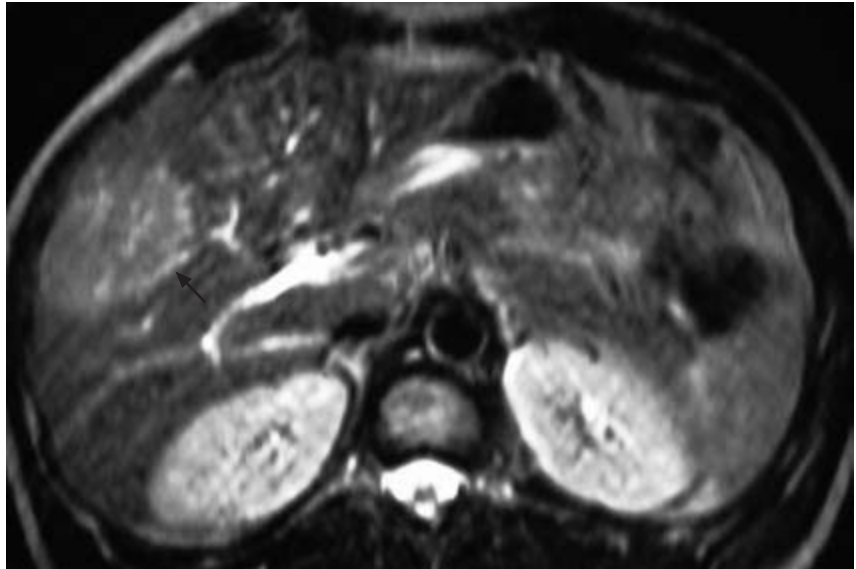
Focal nodular hyperplasia. MRI shows a liver mass in the right lobe (arrow), homogeneously hypervascular after intravenous gadolinium and with a hypo-intense central area.
